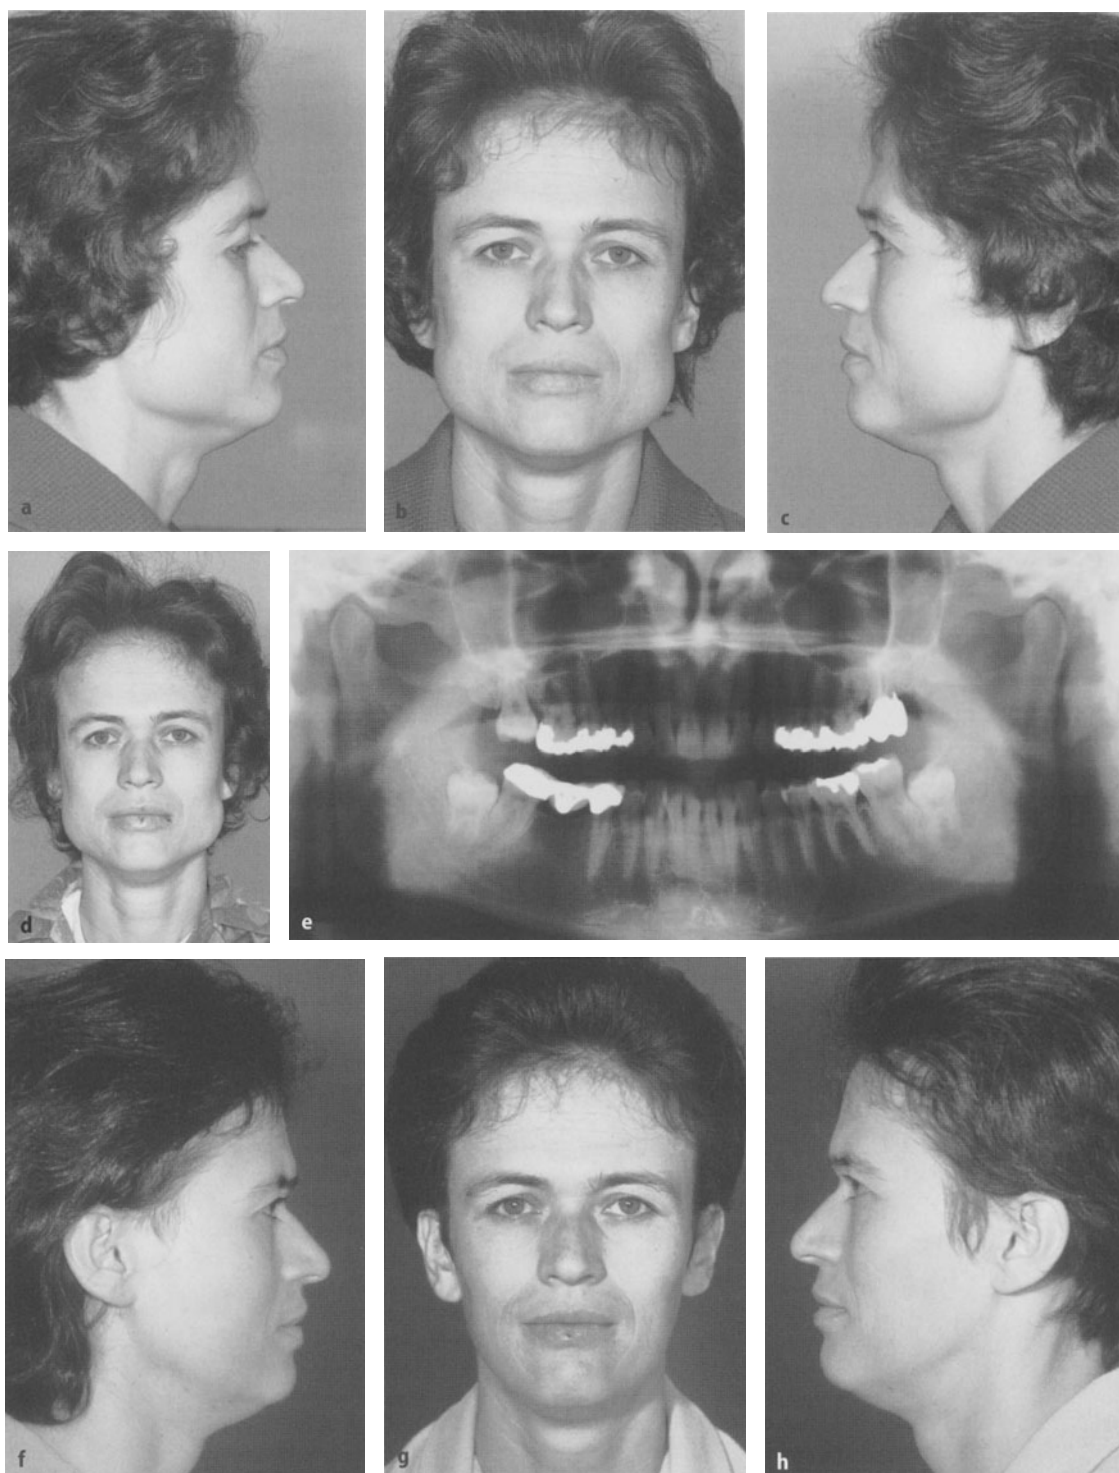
Bilateral pseudo H.H. in a case of bilateral symmetrical masseter hypertrophy. a–c The patient's appearance from in front and both profile views. d When closing the teeth forcibly, the masseter muscles as well as the temporalis muscles become very disturbingly ugly. e The panoramic radiograph discloses a mandible within the normal shape and structure except for very strong angles. f–h. Bilateral pseudo H.H. in a case of bilateral symmetrical masseter hypertrophy. f–h The patient's appearance from in front and both profile sides, 1 year after surgical correction
